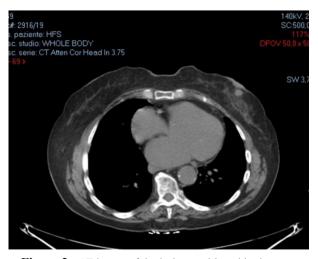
CT image of the lesion positioned in the retro areolar area.
